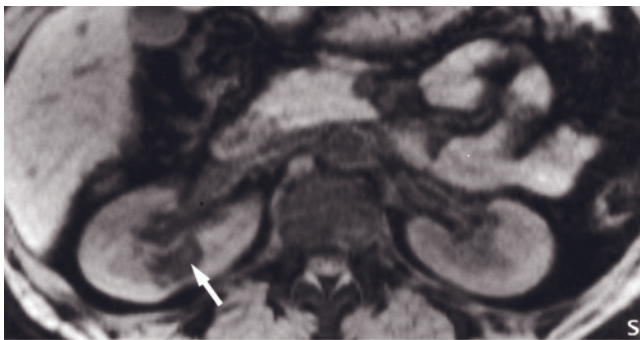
Kidney cancer, subtraction image. SGE (a), 1-min postgadolinium SGE (b), and 1.5-min postgadolinium fat-suppressed SGE (c) images and subtraction image of precontrast from postcontrast image (d). The kidney lesion is heterogeneous and slightly high signal on precontrast images, with a heterogeneous postcontrast appearance that is suggestive but not definitive for cancer. The subtraction image clearly reveals that stromal enhancement of the lesion is present, consistent with cancer. Complex cyst, subtraction image. Transverse T1-weighted SGE image (e), transverse T1-weighted postgadolinium true late hepatic arterial-phase SGE image (f), and coronal T1-weighted postgadolinium fat-suppressed interstitial-phase 3D-GE image (g) and its corresponding subtraction image (h) demonstrate a complex cyst (thick arrows, e–h) of the left kidney in another patient. The complex cyst shows heterogeneous high signal on T1-weighted images, suggesting the presence of subacute blood products or proteinaceous material. The complex cyst is septated (e, f), has a thin wall (e, f), and contains solid components that show hypointense signal suggesting the presence of chronic hemorrhage or calcification (e, f). Subtraction image does not show any stromal enhancement in the complex cyst. Note that there is a small simple cyst (thin arrows, e, f) in the right kidney.
